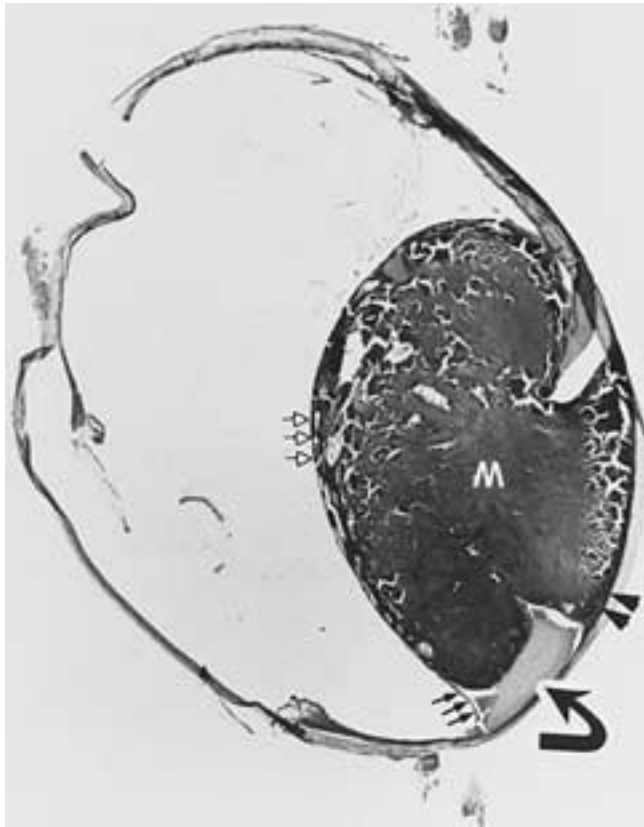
Uveal melanoma. Tissue section shows a mushroom-shaped uveal melanoma (*M*) arising from the choroid (*arrowheads*) and breaking through Bruch's membrane (*curved arrows*). The retina (*open arrows*) is elevated to the top of the tumor and is detached (*arrows*) at the slope of the tumor. (From Mafee MF et al. Malignant uveal melanoma and similar lesions studied by CT. *Radiology* 1985;156:403–408.)
